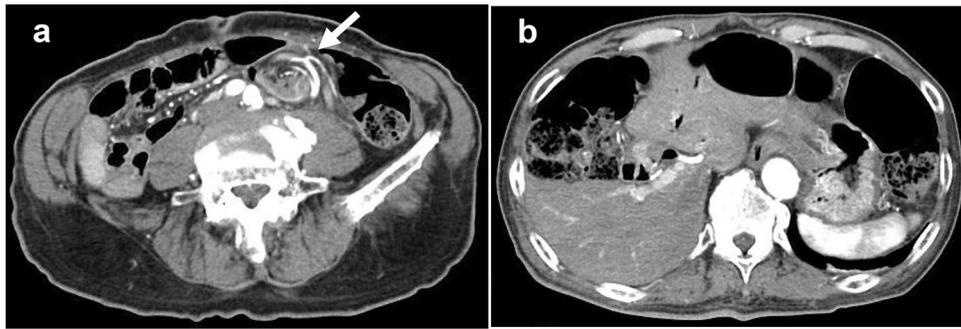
Computed tomography (CT) with contrast medium. The slice at the location of abdominal tenderness showed a soft-tissue mass consisting of swirling intestinal wall, vessels, and mesenteric adipose tissue, i.e., whirl sign (a: arrow), which was highly suggestive of intestinal volvulus. The mesenteric artery is clearly enhanced by
